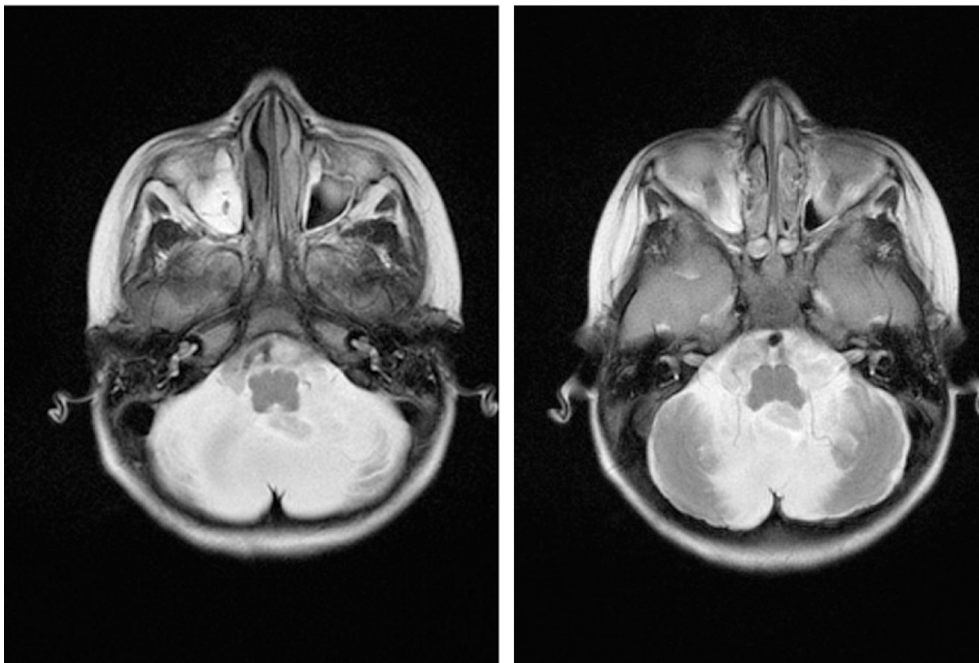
Transversal MRI of the brain of a child with Joubert syndrome
